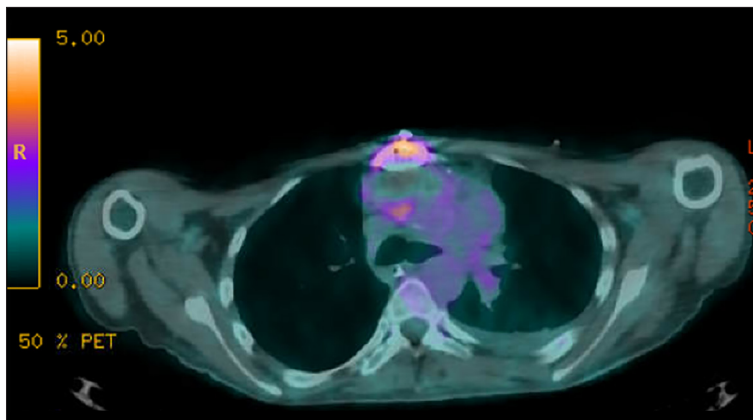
Positron emission tomography-computed tomography scan (axial view) showing fluorodeoxyglucose-avid uptake along the sternotomy wires and fluid collection in the anterior mediastinum corresponding to the pseudoaneurysm.
